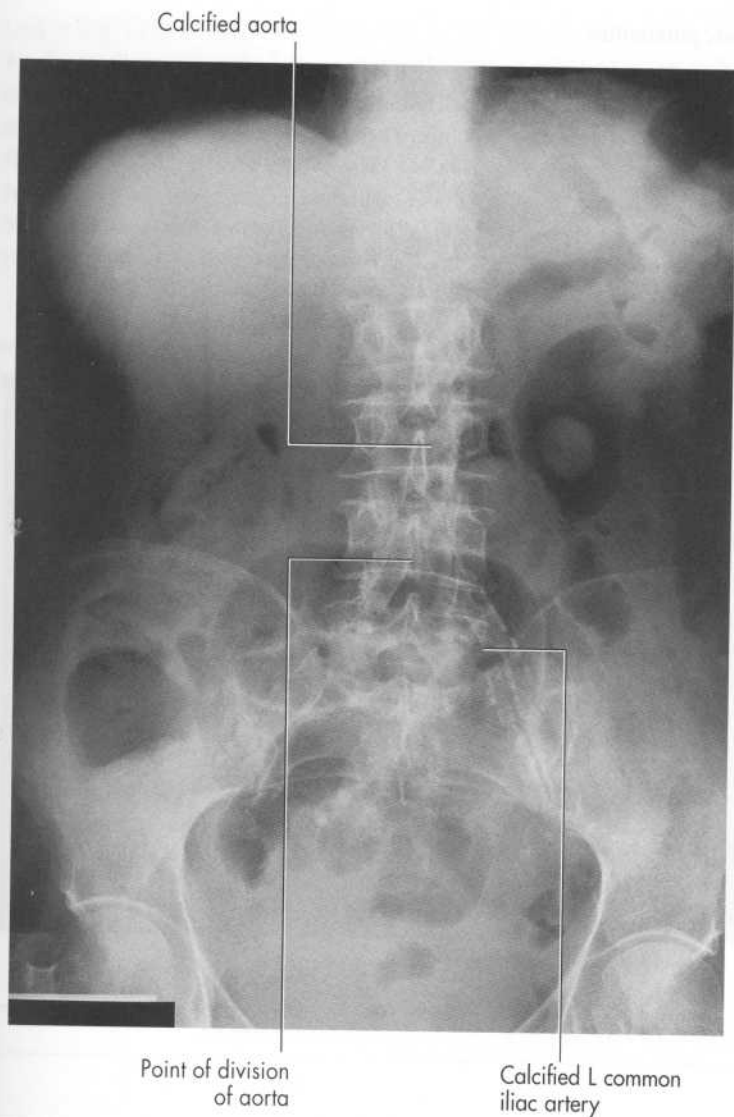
Supine AP radiograph of a 68-year-old woman.
